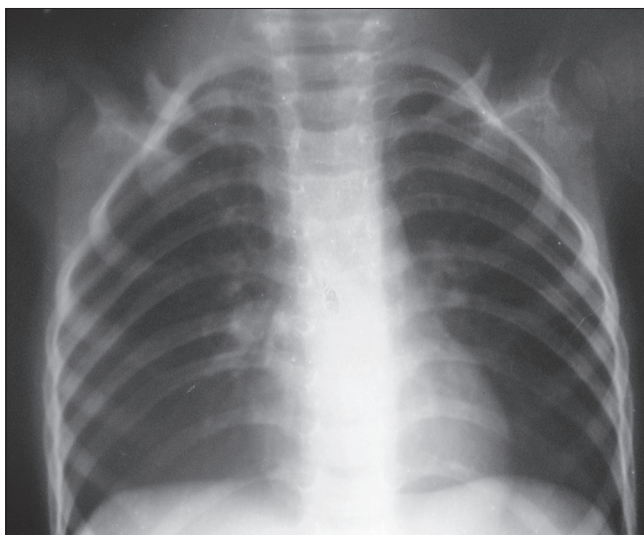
X-ray of the chest showing a pyriform thorax, overcrowding of proximal ribs, and short clavicle with pointed lateral ends
